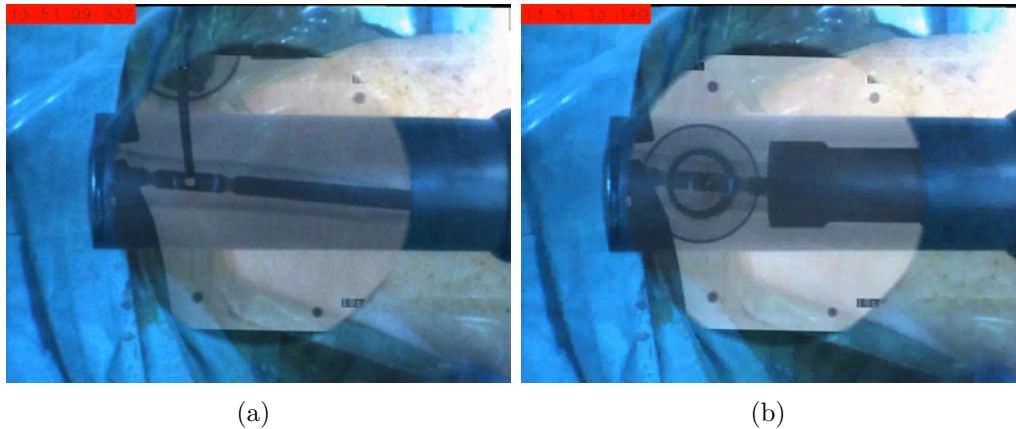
(a) Orienting the drilling axis to be aligned with the down-the-beam axis using the X-ray and video image overlay; (b) Alignment is confirmed by the X-ray image showing embedded radiolucent cylinder structures inside the drill machine imaged as two co-centric round circles.
